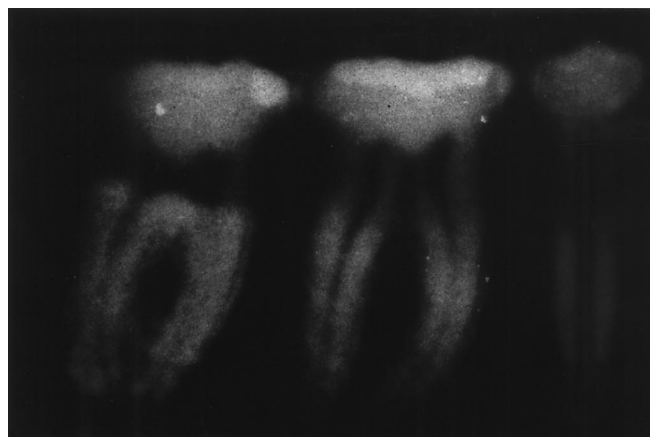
Victim's dental x-ray which permits an exact evaluation of the restoration of the first and second inferior right molars
